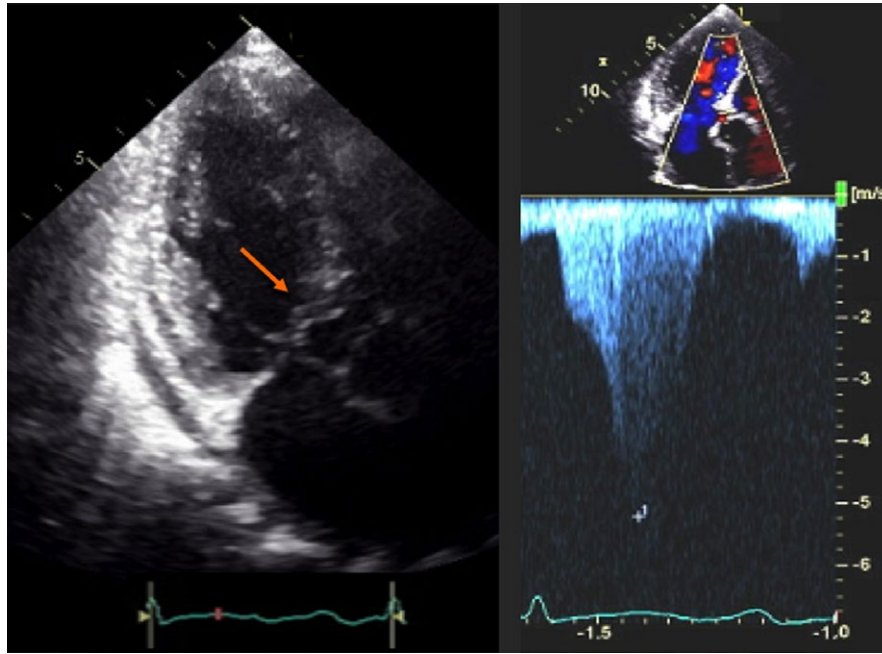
Ballooning event of 66-year-old female with known hypertrophic cardiomyopathy and systolic anterior motion (SAM) but not previously known to obstruct presented acutely with chest pressure, shortness of breath and syncope. Frame A and B: Parasternal long-axis view in diastole (A) and systole (B). The frames demonstrate the septal bulge (red arrow), SAM with mitral-septal contact (orange arrow), and akinetic anteroseptum (white arrowheads). Panel C, CW Doppler with resting left ventricular outflow tract gradient of 88 mm Hg. Panel D, Systolic LV cine-angiographic frame on admission with apical and mid-LV ballooning
